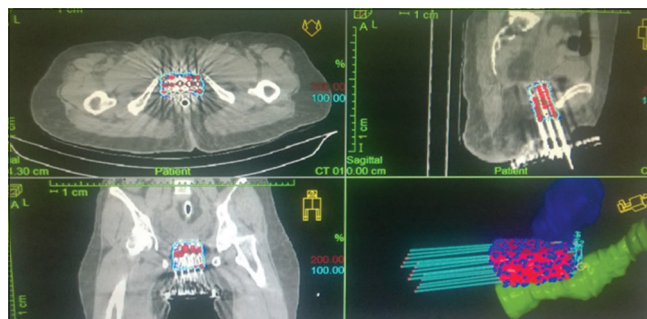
CT scan images with reconstructed needles and plan generated
